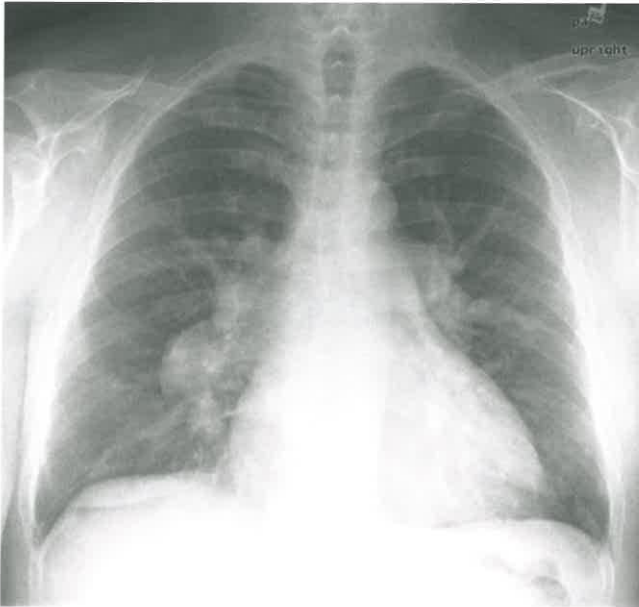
Bilateral Hilar Enlargement in Pulmonary Arterial Hypertension. Frontal chest radiograph shows marked central pulmonary arterial dilatation with attenuation of peripheral vasculature (“pruning”) in a patient with severe pulmonary arterial hypertension due to COPD.
